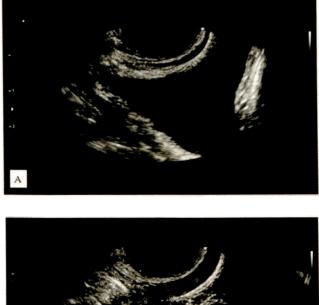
Transrectal ultrasound showed urethra and urinary bladder are smooth and intact but there is absent triple line sign of the vagina (A); cervix measured $1.5 \text{ cm} \times 0.9 \text{ cm} \times 0.5 \text{ cm}$ and the anteverted uterus measured $2.4 \text{ cm} \times 0.7 \text{ cm} \times 0.5 \text{ cm}$ (B).
